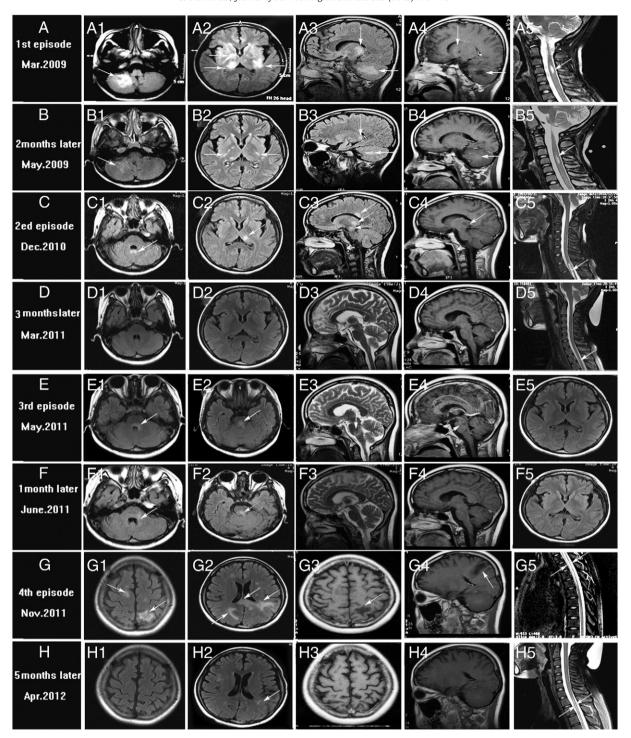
Serial MRI findings in the brain and spinal cord. (A) Fluid-attenuated inversion recovery (FLAIR) T2 weighted image, showing large lesions with poorly defined margins in the right cerebellum (arrow, A1), the bilateral basal ganglia and thalamus (A2, A3) and cloud-like Gd enhancement on T1-weighted imaging (A4). Lesion in the spinal cord (A5). (C) T2-FLAIR showing new brain lesions in the midbrain (C1), thalamus, corpus callosum (C2,C3) without enhancement (C4) and a centrally located longitudinal spinal cord lesion from C7 to T12 (C5). (E) New lesion in the brain stem along the aqueduct with poorly defined margins on T2-FLAIR (E1, E2) and sagittal T2 MRI (E3), with no enhancement on Gd-T1 (E4). (G) T2-FLAIR showing large new lesions in the cortical (G1), corpus callosum and subcortical white matter (G2), without enhancement (G3, G4). Enlargement of the lesions in the spinal cord from C6 to T10 (C5). (H) MRI results 6 months after stopping INF-β therapy.
